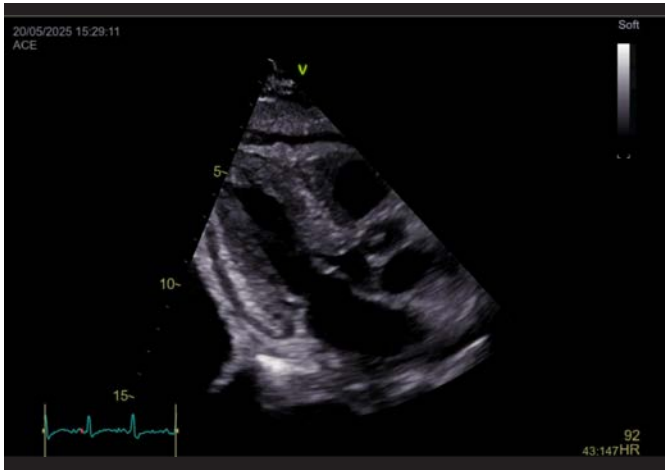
Transthoracic echocardiography demonstrating marked hypertrophy involving all cardiac chambers and valves, with a hyperechoic myocardium displaying an infiltrative appearance, associated with circumferential pericardial effusion.
